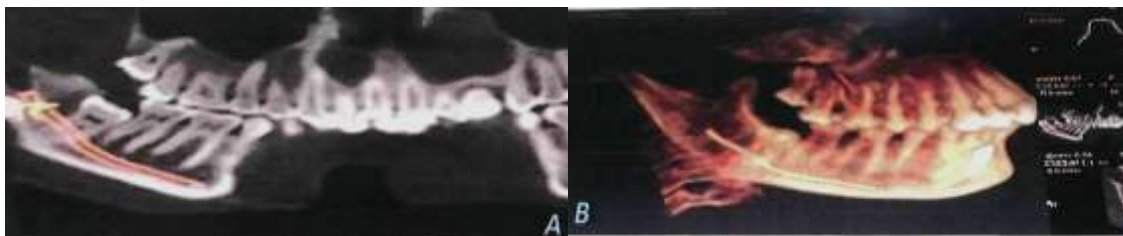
A: The panoramic radiograph with collimation on the right molar area reveals the lingual position of the mandibular canal B: 3D view
